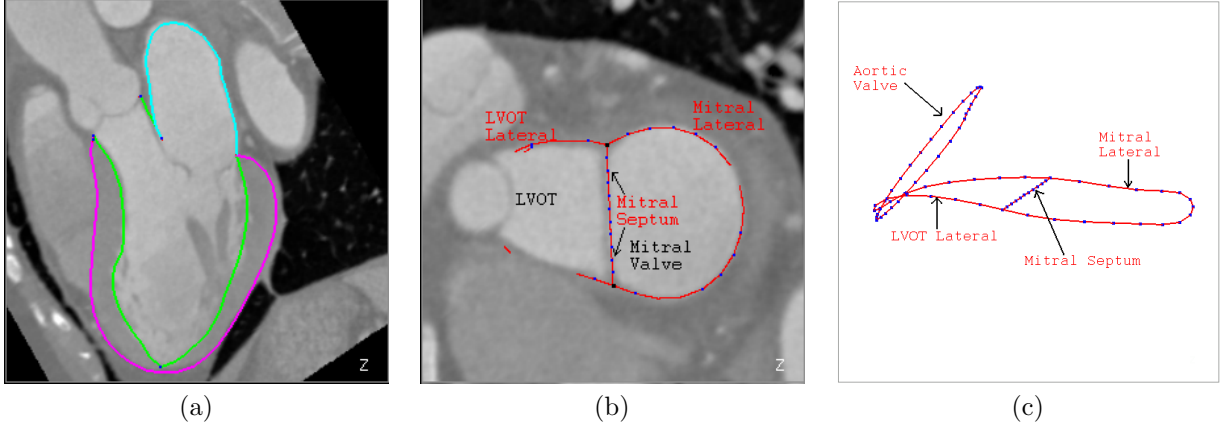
Control points for delineating the left ventricle (LV) and left atrium (LA) meshes. (a) LV/LA mesh embedded in a CT volume. (b) Control points around the mitral valve. Since the curves are 3D, only parts of mitral lateral and LVOT lateral are visible on a specific plane. (c) Control points of mitral valve and aortic valve in a 3D view.
